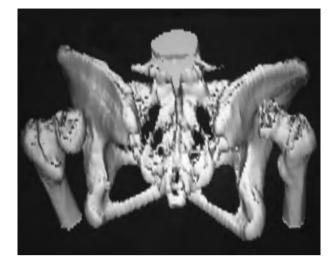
Reconstruction of 3D CT scan: bilateral hip dislocation.
